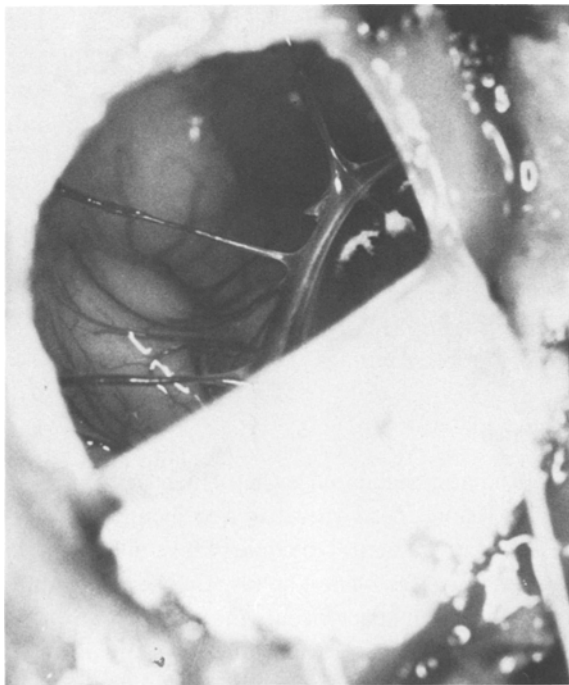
Some hanging vein crossing the cyst corresponds to linear shadows in the contrast CT
